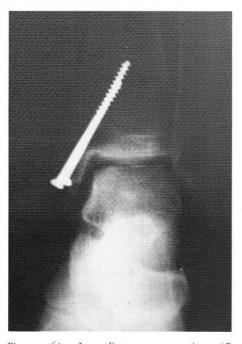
Immediate postoperative AP radiograph. Note the alignment of the subchondral bone of the ankle as well as minimal visibility of the malleolar osteotomy.
